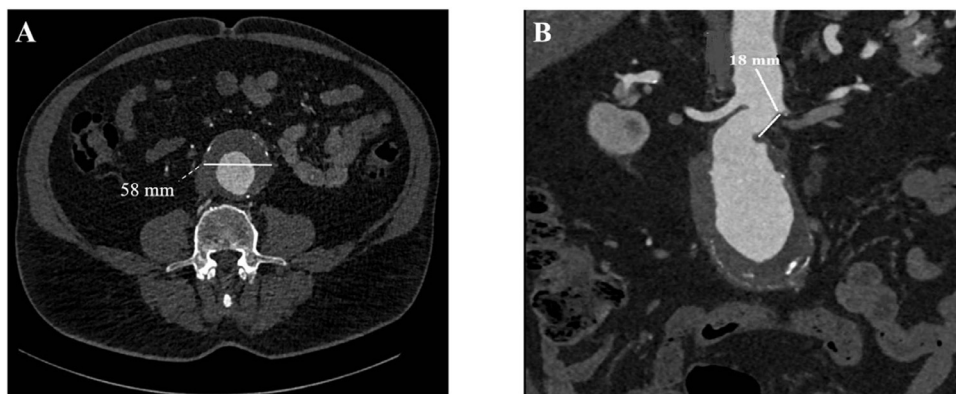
(A) Computed tomography angiography showed the therapeutic-size infrarenal abdominal aneurysm of 58 mm (B) with the short infrarenal neck of 18 mm.
